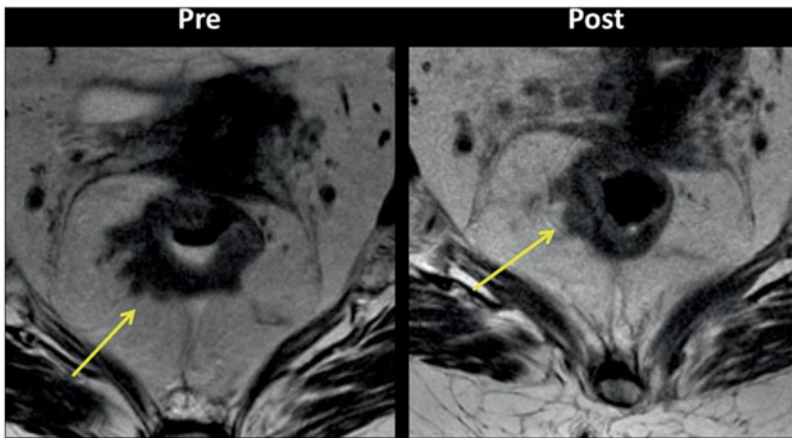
Pelvic magnetic resonance imaging (*MRI*) findings demonstrate incomplete response after neoadjuvant chemoradiotherapy
